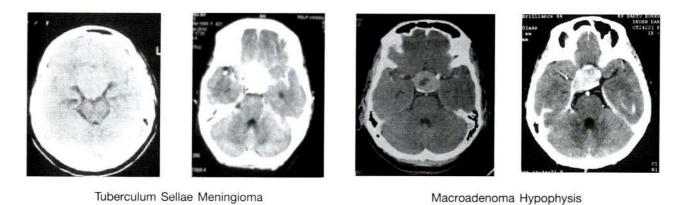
Tuberculum sellae meningiomas appear distinctively homogeneous and enhance entirely after application of contrast. On the contrary, macroadenoma hypophysis have various CT appearance with minimal contrast enhancement
